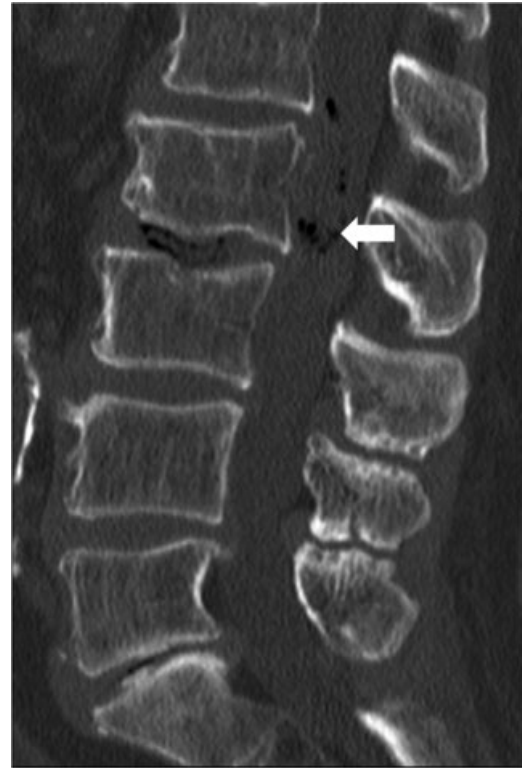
Sagittal bone window of lumbar computed tomography scan. The vacuum phenomenon with evidence of intraspinal gas present at L2-L3 was initially attributed to gas-forming bacteria as spinal infection was suspected based on clinical presentation and pathologic laboratory values (arrow).
